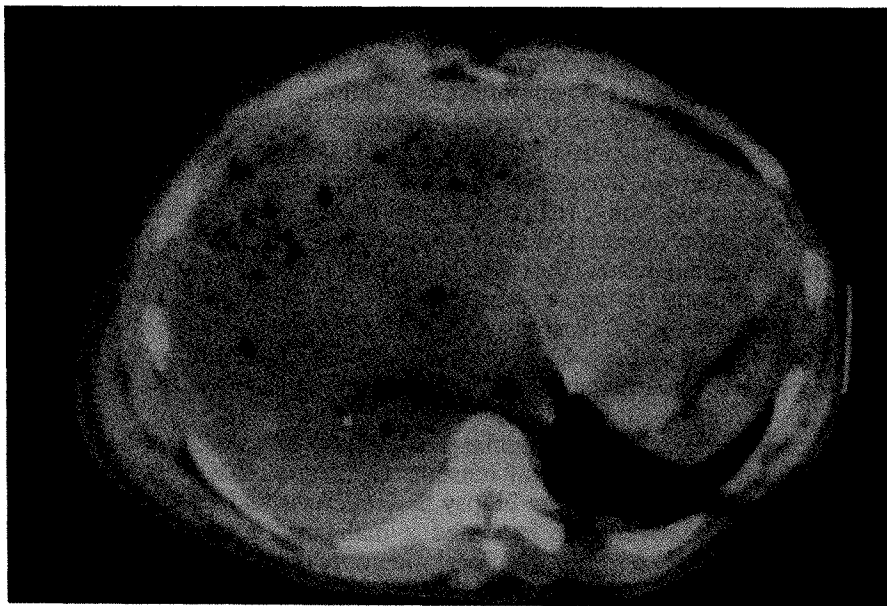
Preoperative CT-scan showing a low-density, heterogeneous mass ( $17.5 \times 16$  cm), with areas of lower density and calcifications.
